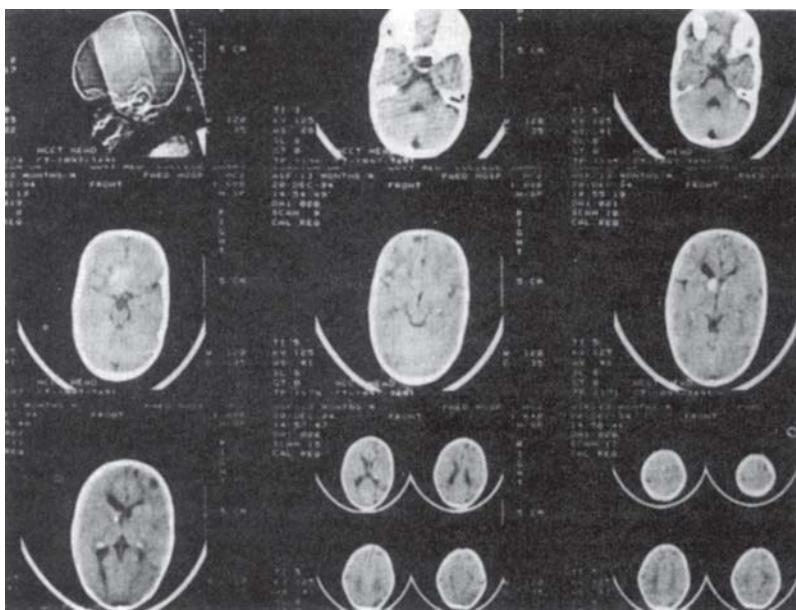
Computed tomography (CT) scan of skull.* Note the findings suggestive of multiple sclerosis and the large space-occupying lesion in the left frontal area
